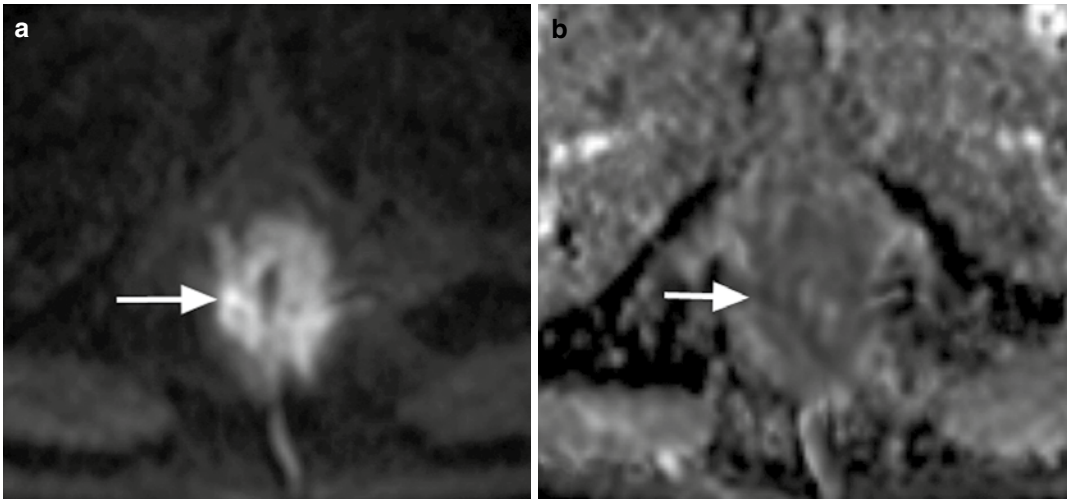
A man with carcinoma of the anus. (a) $b=900$ s/mm² DWI image shows abnormal high signal and thickening of the anal canal (arrow). (b) ADC map returns low signal intensity and ADC values (arrow)
